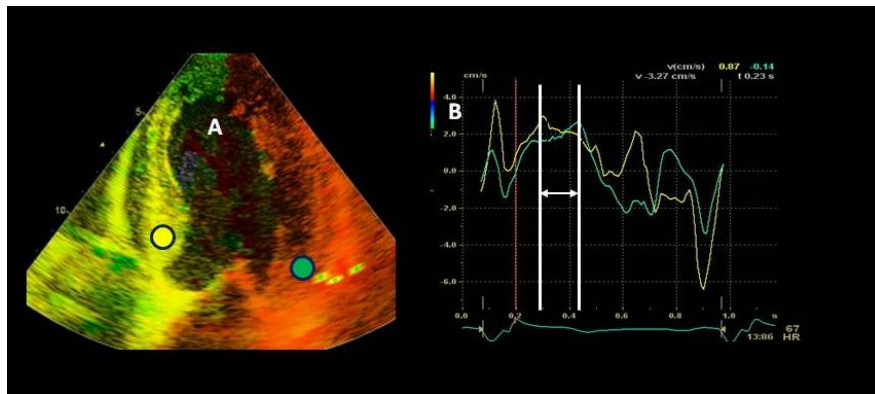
Mesure de l'asynchronisme entre le septum et la paroi latérale sur les courbes de l'imagerie BD en Doppler couleur.
